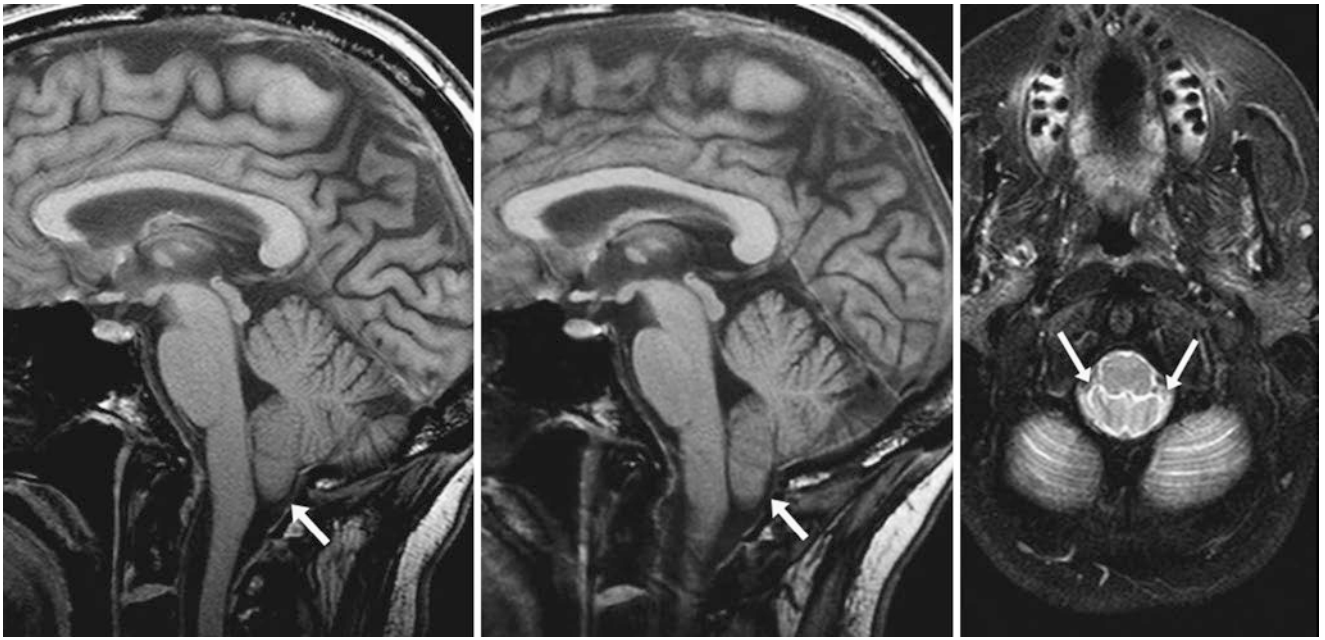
A 49-year-old patient with a 1.5 T MRI performed for mild cognitive impairment noted mild 5.8 mm of tonsillar ectopia (*arrows*) on sagittal T1WI (*left*) and was unchanged 6 months later (*middle*). The patient did not have headaches. Axial T2WI (*right*) depicts
